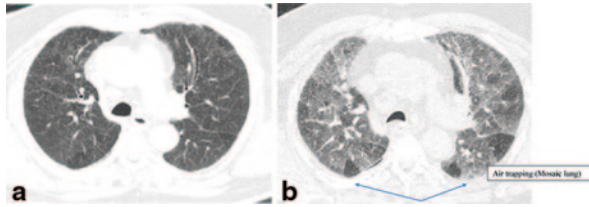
a Inspiratory CT scan of the chest. b Expiratory phase CT scan chest in a patient with BOS. *CT* computed tomography, *BOS* bronchiolitis obliterans syndrome
